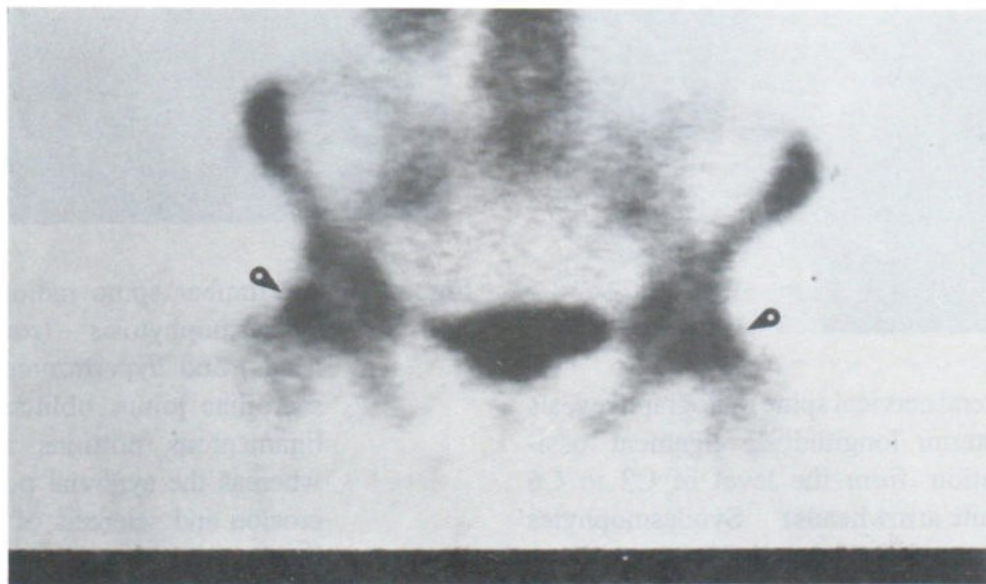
Bone scintigram reveals foci of increased radiotracer uptake at femoral head-neck regions (round arrowheads).
